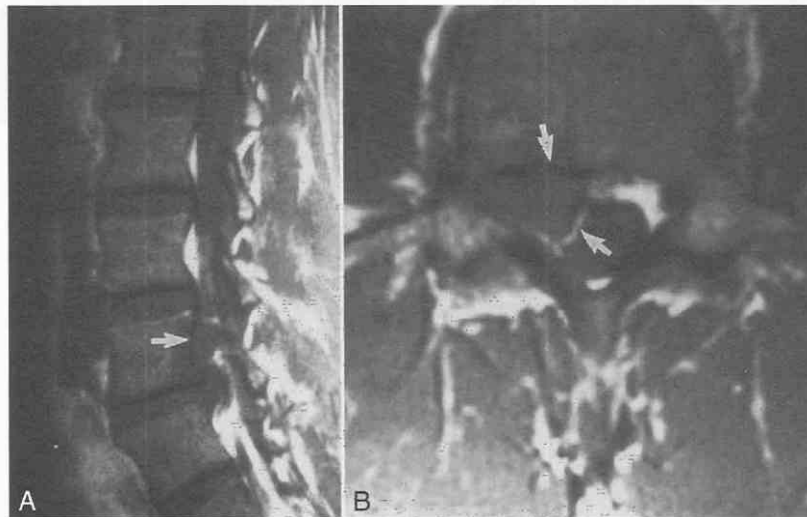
Sequestered disk. A, Sagittal MR image shows an L4-5 disk fragment (arrow) lying posterior to the L4 body. B, Axial MR image shows the fragment (arrows) obliterating the L4 root in the right lateral recess and pressing on the thecal sac. See also Figure 22-24H and I.
